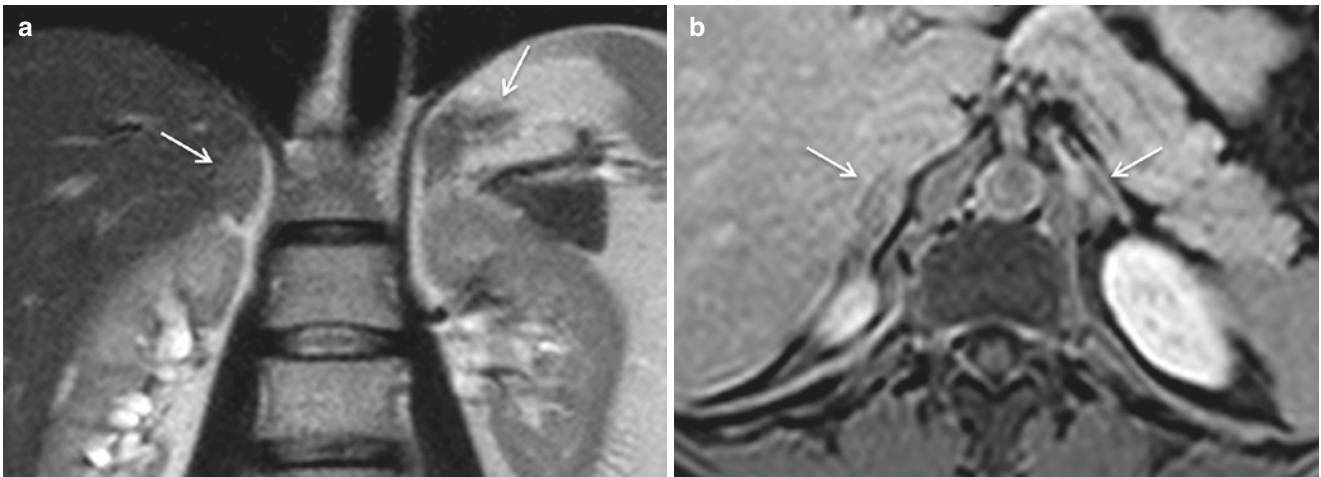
Adrenal hyperplasia. Diffuse enlargement of both adrenal glands on coronal T2-weighted MRI (a) and axial T1-weighted post-gadolinium (b) images (white arrows)
